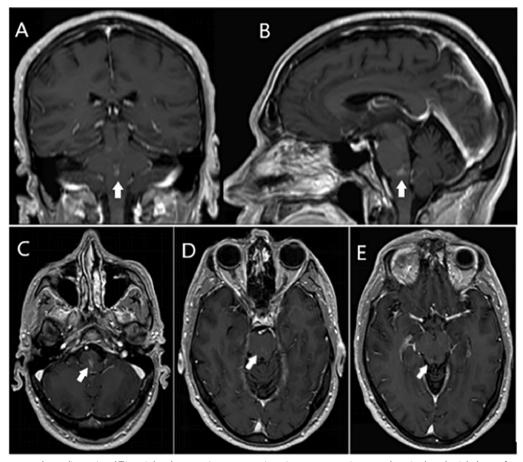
Post-contrast three-dimensional T1-weighted magnetic resonance imaging sequences in coronal, sagittal, and axial planes. A Heterogeneous enhancement in the midbrain tegmentum (white arrow). B Contrast enhancement in the posterior region of the pons (white arrow). C Subtle enhancement in the medulla oblongata (white arrow). D Patchy enhancement in the pons (white arrow). E Mild enhancement in the midbrain (white arrow)
